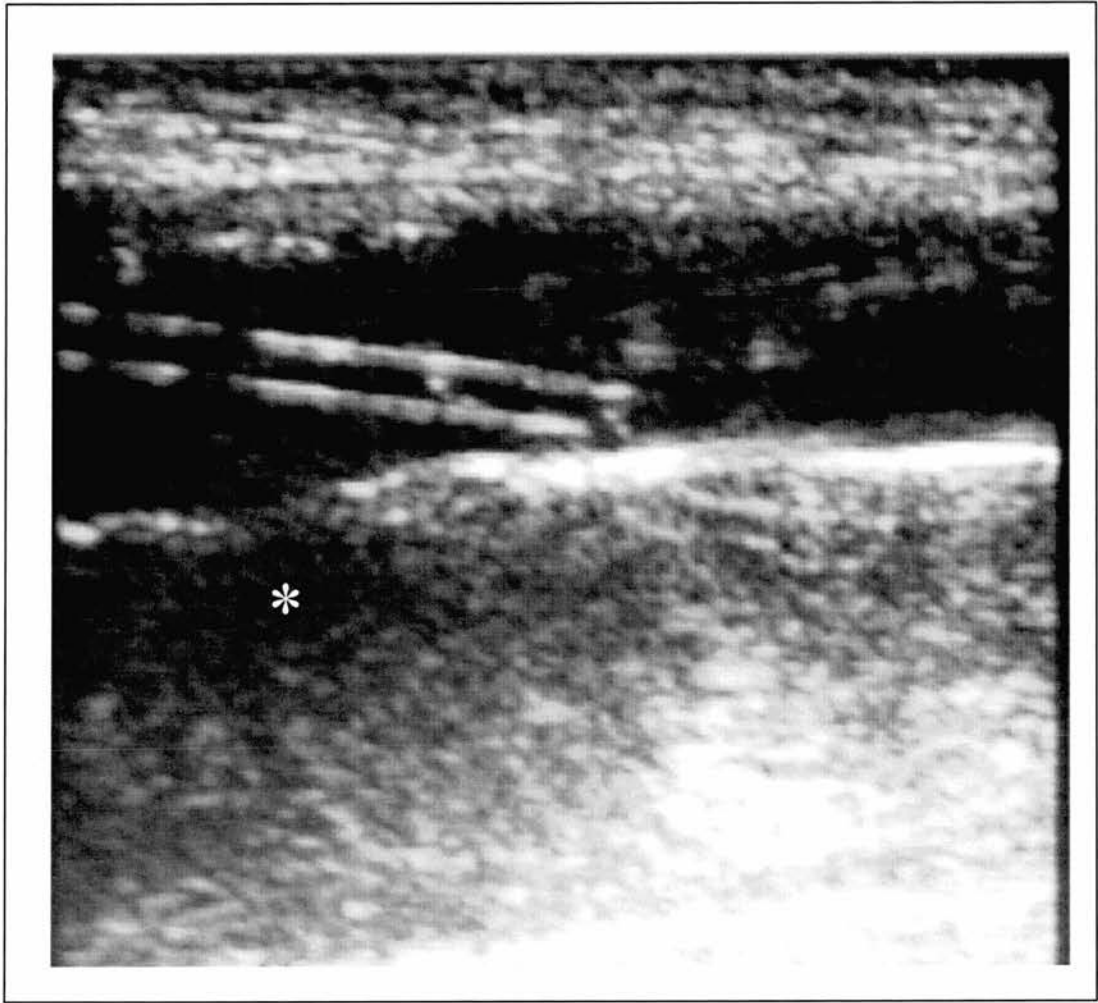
Ultrasound image of compartment pressure catheter alongside a tibial fracture (*)
